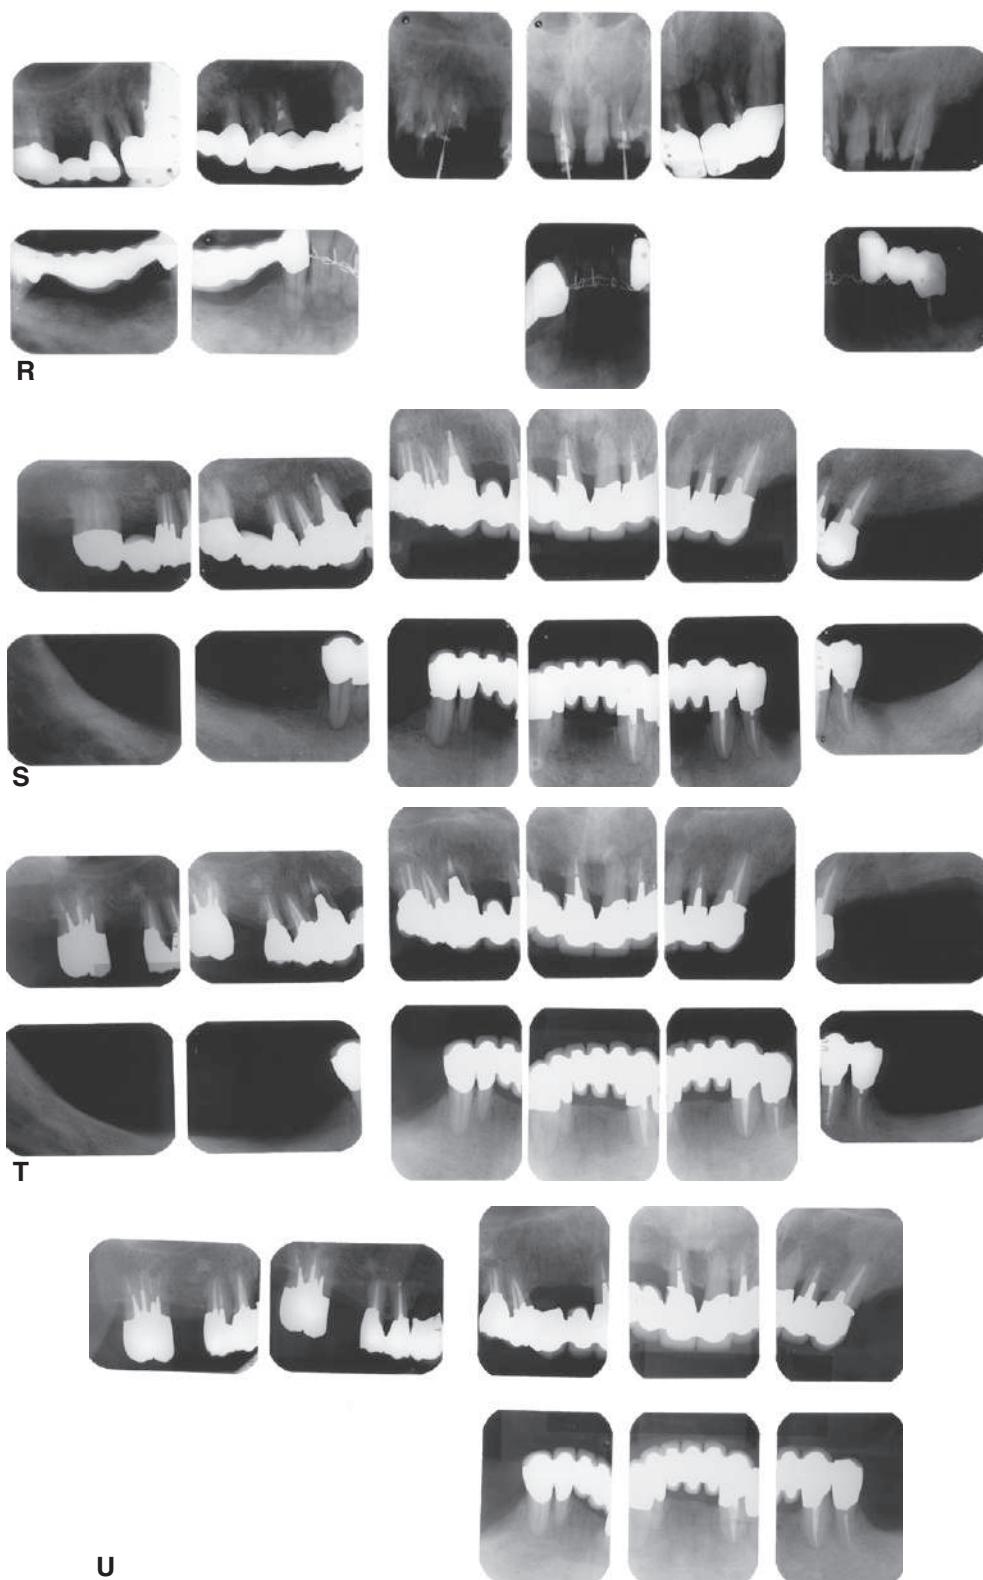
Cont'd (R) Preoperative radiographs. (S) Postoperative radiographs. (T) Eight-year postoperative radiographs. (U) Seventeen-year postoperative radiographs. A fixed partial denture (FPD) was fabricated, replacing the missing tooth #3 with teeth #5, #4, and #2 as abutments. The teeth were prepared with minimal taper, and the castings exhibited good retention. After 10 years, the FPD failed when tooth #2 became dislodged, possibly as a result of the additional loading by the removable partial denture (RPD). Tooth #2 and the pontic were removed, endodontic treatment was performed, a new crown was fabricated, and the #3 pontic was incorporated in a new RPD. Tooth #6 was lost as a result of internal resorption and caries. Initially, the tooth was discolored, but the lesion was inactive, and the attempt to save it failed after 8 years. Its guarded prognosis was discussed as a significant risk factor before treatment initiation. This suggests that teeth with a guarded prognosis can be maintained if attention is paid to the principles of casting adaptation and occlusion.
